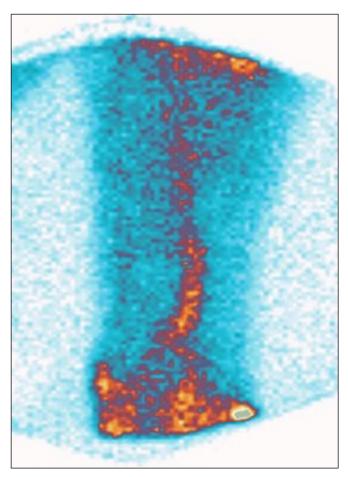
Radioisotope phleboscintigraphy in a horizontal position: patent IVC after cavaplication *Picture taken by the authors*
